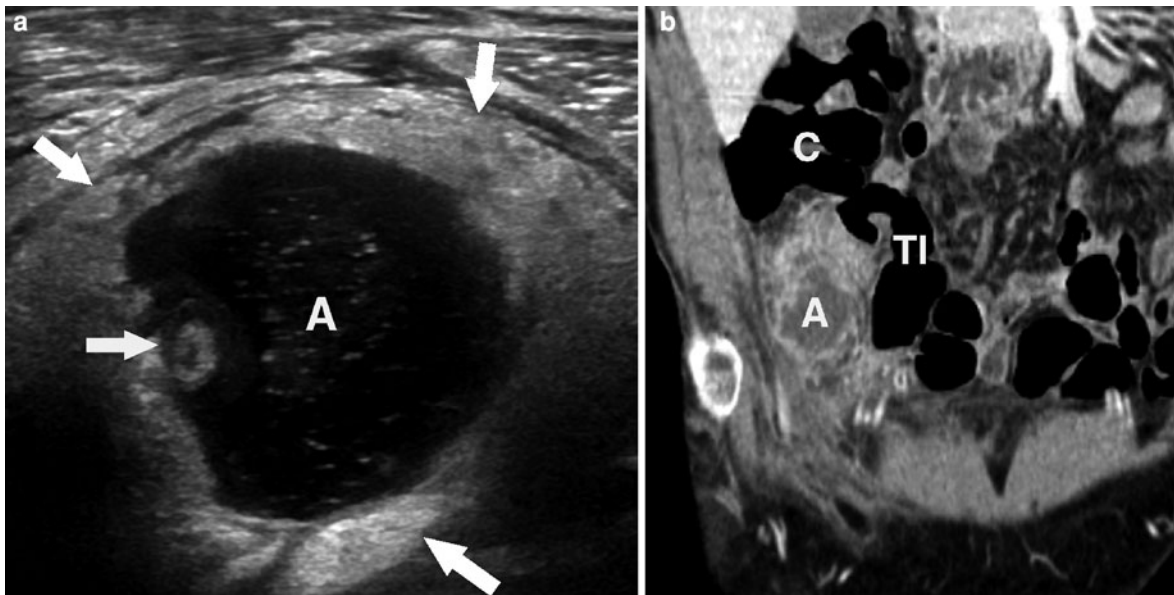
a, b Periappendiceal abscess on ultrasound and CT. In a, transverse grayscale sonogram demonstrates complex fluid collection (“A”) walled-off by surrounding echogenic fat (*black arrows*). Small residual of appendix is noted along lateral aspect of abscess cavity (*white arrow*), indicating origin
